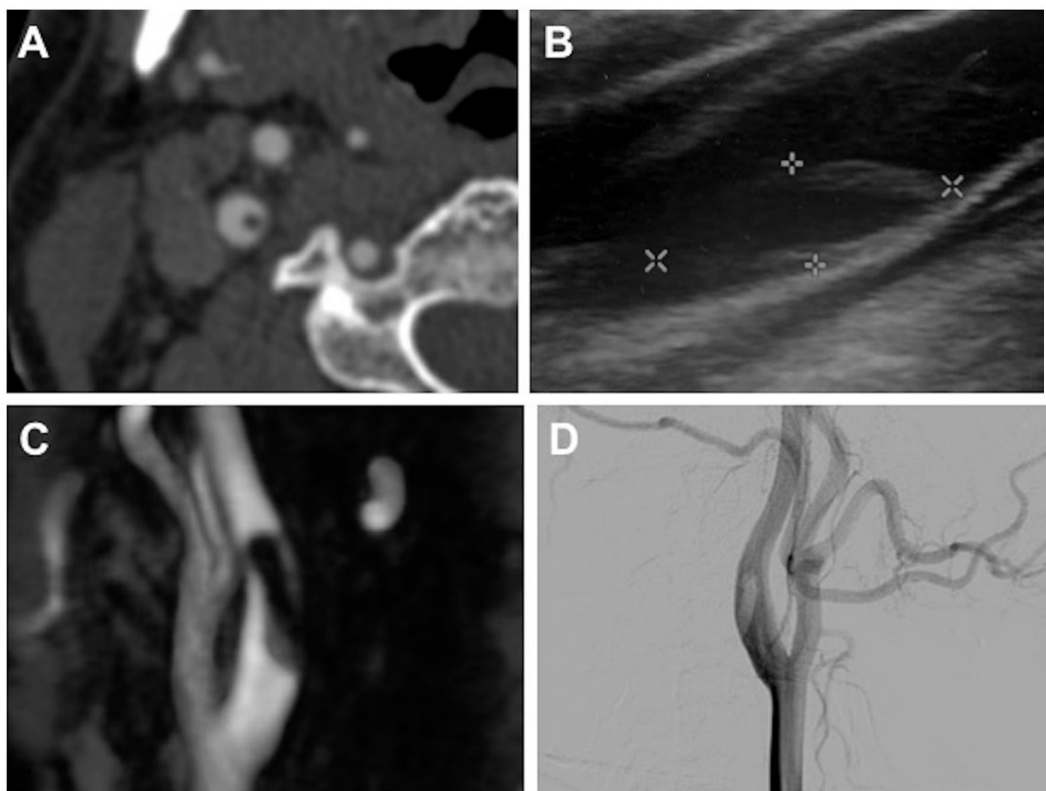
Different images of the carotid FFT. Angio-CT with the donut sign (A), carotid Doppler (B), angio-MR with the finger sign (C) and angiography with the finger sign (D)
